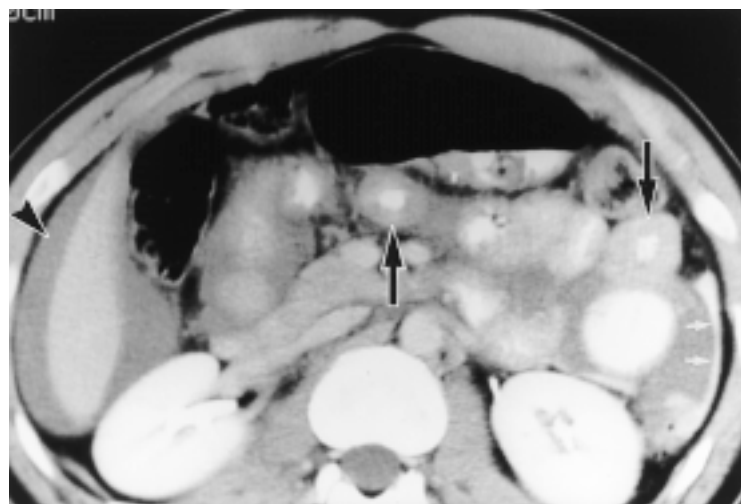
A 10-cm-long jejunal laceration and mesenteric avulsion of the descending colon in a 35-year-old man. CT scan demonstrates thick-walled jejunal loops (black arrows), hemoperitoneum (arrowhead), and free intraperitoneal contrast material (white arrows).
